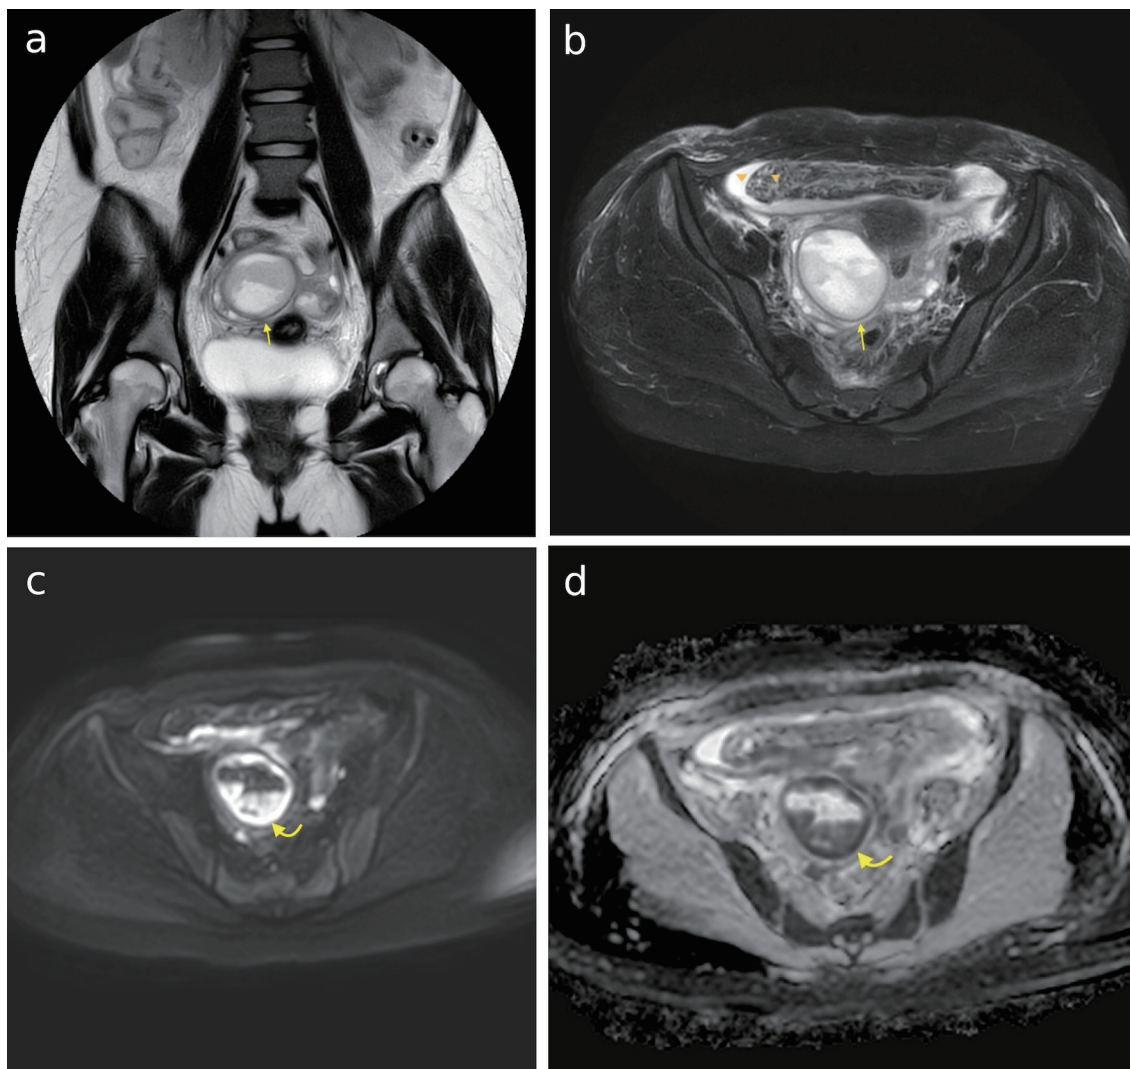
(a) Coronal T2-weighted image of the abdomen shows a highly heterogeneous complex cystic lesion in the right side of the pelvis (arrow). (b) Axial T2-weighted fat-saturated image shows a large complex cystic lesion in the right side of the pelvis (arrow), displacing the right adnexa inferiorly. Fat stranding and free fluid are also present (arrowheads). (c) Axial DWI image at $b = 1,000 \text{ s/mm}^2$, showing areas of high signal intensity within the lesion (curved arrow). (d) Same areas depict low signal in the ADC map corresponding to areas of restricted diffusion (curved arrow). DWI: diffusion-weighted imaging; ADC: apparent diffusion coefficient.
